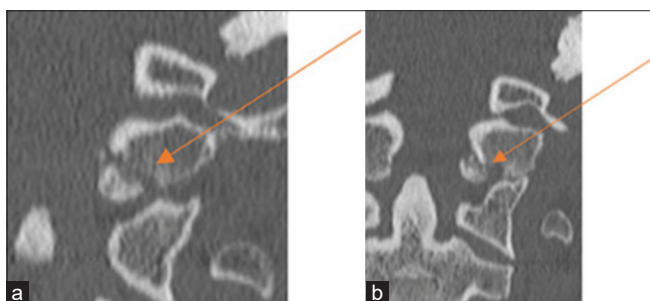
(a) A 32-year-old unrestrained MVC with left Type III occipital condyle fracture. (b) One-month interval CT cervical spine – a 32-year-old unrestrained MVC with left Type III occipital condyle fracture managed with cervical collar with early signs of cortication of fracture
